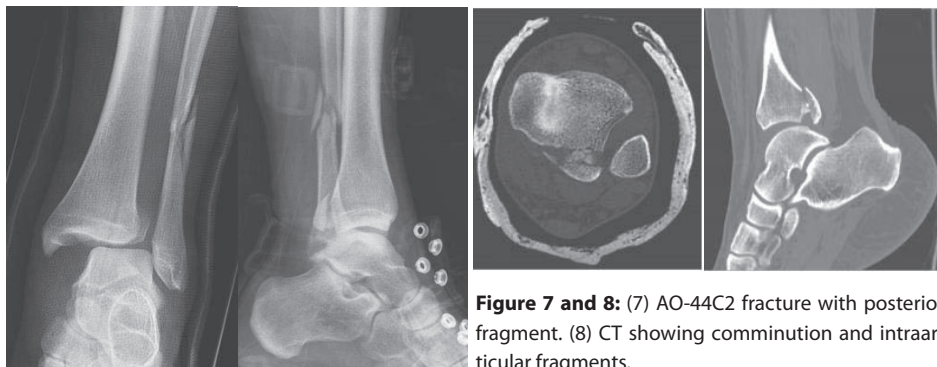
(7) AO-44C2 fracture with posterior fragment. (8) CT showing comminution and intra-articular fragments.
